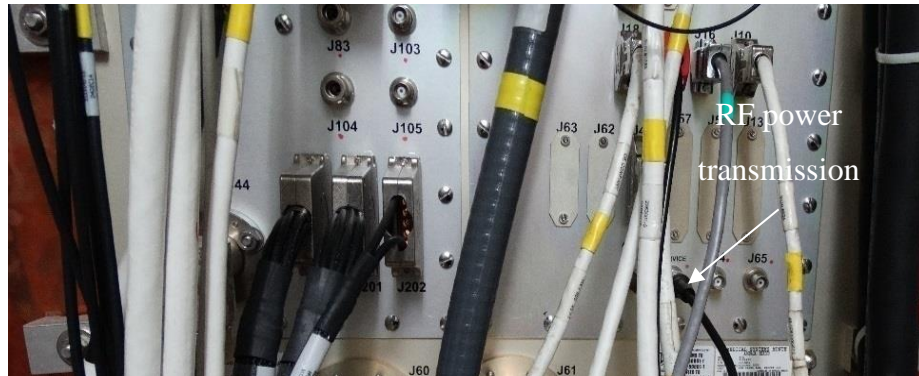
RF transmission connection through the MRI's Faraday cage penetration panel.
